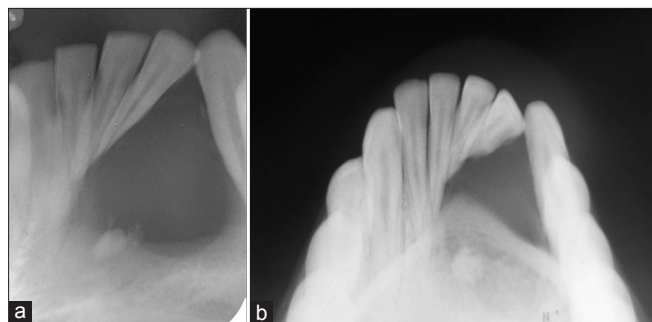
Intraoral radiographic investigation; (a) Anterior Islands organic producers association and (b) Anterior mandibular occlusal topography; showing a bony defect between 42 and 43 with displacement of teeth, root resorption of 42, 43 and a focus of calcification
